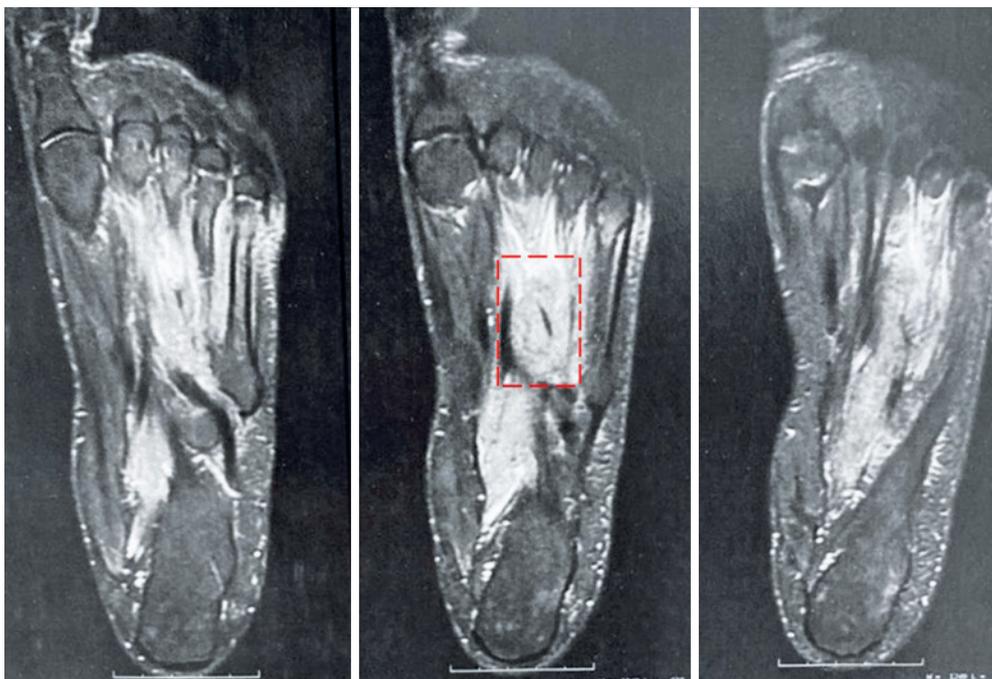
Expansive lesion of superficial and deep soft tissues of the left forefoot and, to a lesser extent, the midfoot, compromising mainly the flexor muscle of the third, fourth, and fifth toes, with hyperintense signal on T2-weighted and an isointense signal on T1 with contrast enhancement.
